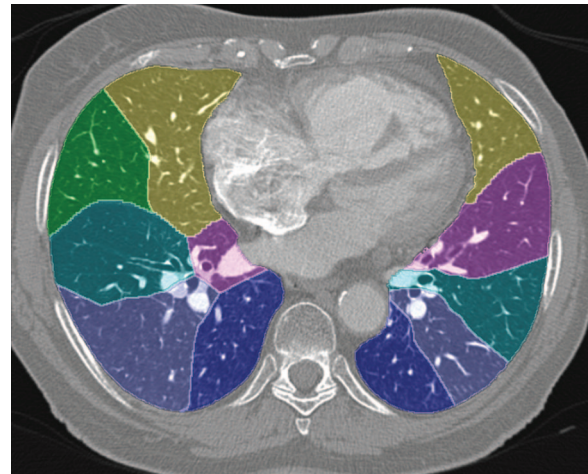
Axial CT image shows the results of estimation of the segments, which are represented by colored overlays with white boundary lines.
